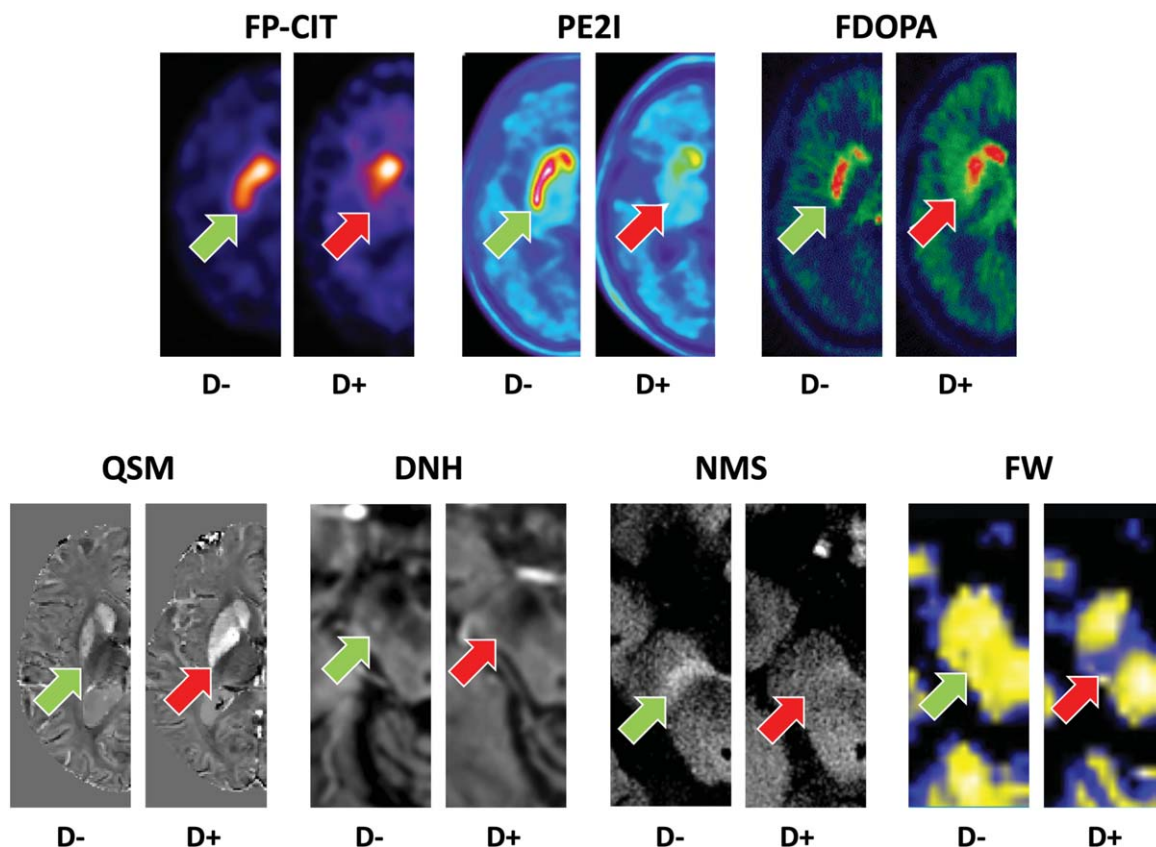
Imaging Biomarkers of Dopaminergic Degeneration in PD. Various PET or MRI modalities can capture dopaminergic degeneration (see Table 1 for availability and use in clinical routine). Examples of normal (D-) and pathological (D+) findings. Red arrows indicate abnormality. Normal findings pointed out with green arrow. All images are in axial orientation. FP-CIT: dopamine transporter SPECT using [123I]FP-CIT; PE2I: dopamine transporter PET using [18F]FE-PE2I; FDOPA: presynaptic dopamine turnover PET using [18F]DOPA; QSM: Quantitative susceptibility mapping MRI of iron load the striatum. DNH: Dorsal nigral hyperintensity in SWI or T2\* MRI, a.k.a. 'swallow tail sign'. NMS: Neuromelanin-sensitive MRI of the substantia nigra; Courtesy Stephane Lehericy, Rahul Gaurav (Paris Brain Institute, France). FW: Free water diffusion MRI of the posterior substantia nigra; Courtesy David Vaillancourt (University of Florida, USA).
